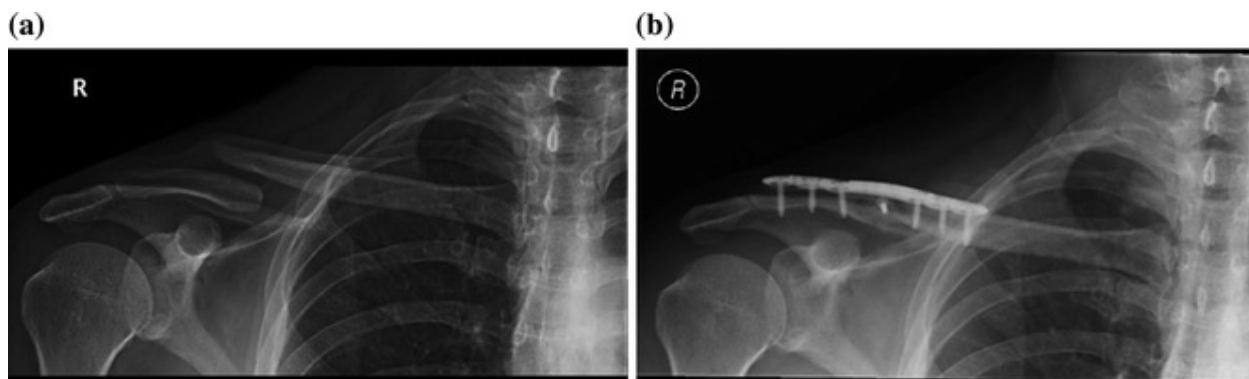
a Preoperative radiograph of midshaft clavicle nonunion in an active 28-year-old man
